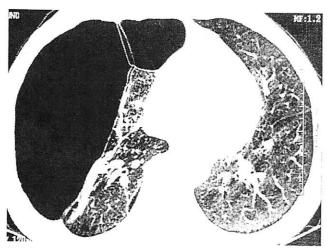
Computed tomography chest scan confirming the presence of a large bulla in the right hemithorax. There is no centrilobular emphysema in the contralateral lung.
